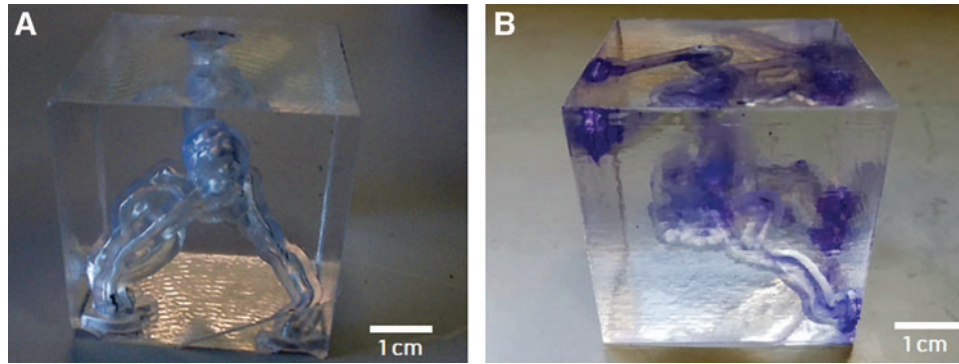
(a) AVM model printed with SLA and embedded in PDMS without (A) and with (B) the presence of the contrast agent in the vessels. AVM, arteriovenous malformation; CT, computed tomography; PDMS, polydimethylsiloxane.
